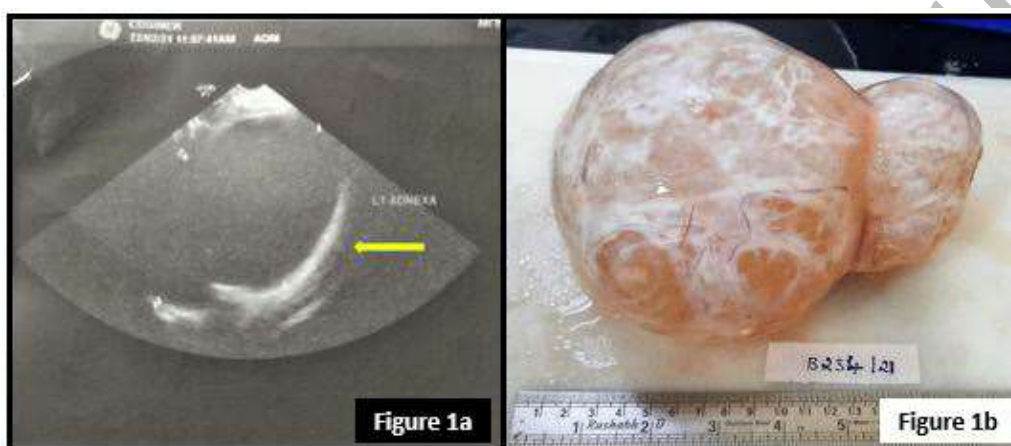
1a - Ultrasound abdomen showing large cystic mass (arrow); 1b - Gross picture of the cystic mass.
